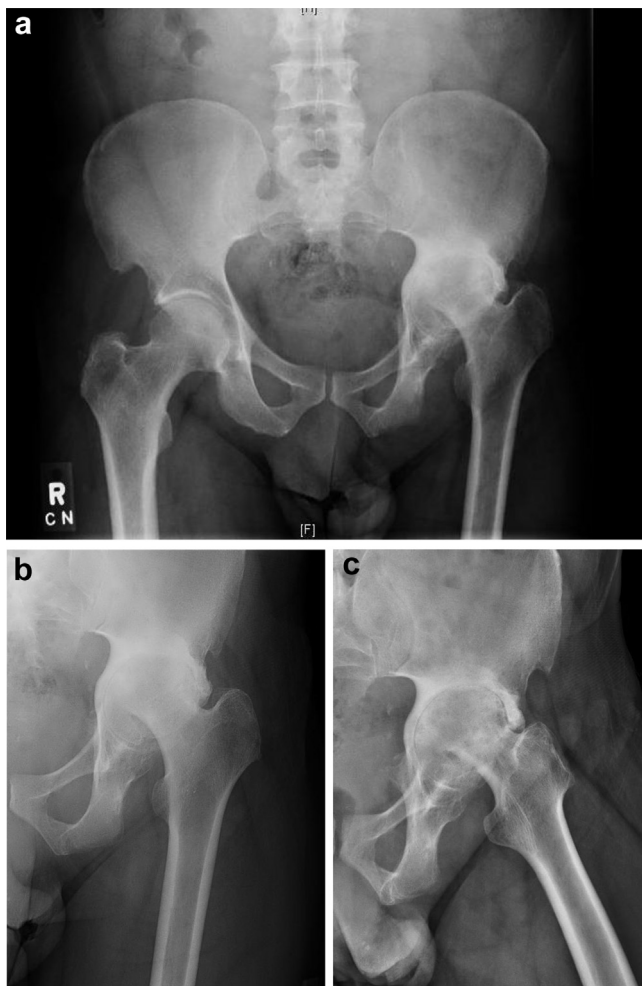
Anteroposterior (AP) pelvis (a), left hip anteroposterior (b), and lateral (c) radiographs demonstrating severe left hip posttraumatic arthritis with significant acetabular protrusion.
